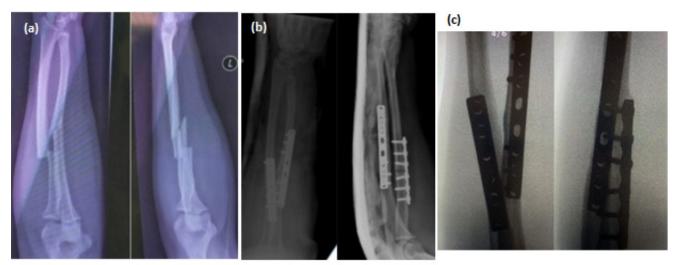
(a) Anterior-posterior and lateral plain radiographs of left forearm demonstrating midshaft fractures of both radius and ulna. The ulna fracture appears to have an oblique configuration with a sharp spike, possibly contributing to transection of the ulna nerve. (b) Anterior-posterior and lateral plain radiographs of left forearm after dynamic compression plating demonstrating restoration of bony anatomy that provides secure splintage for the vein graft conduit.(c) Anterior-posterior and lateral image intensifier images of the left forearm demonstrating successful union of the radius and ulna fracture 2 months post-surgery.
